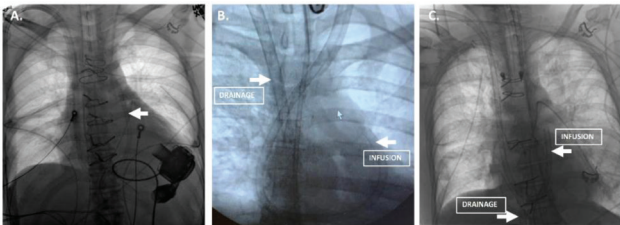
Chest radiographs demonstrate placement of A) PtD with right IJ cannulation, B) Bilateral RU+LIJ cannulation and C) Fluoroscopic-guided RU+IV cannulation for right ventricular support.
